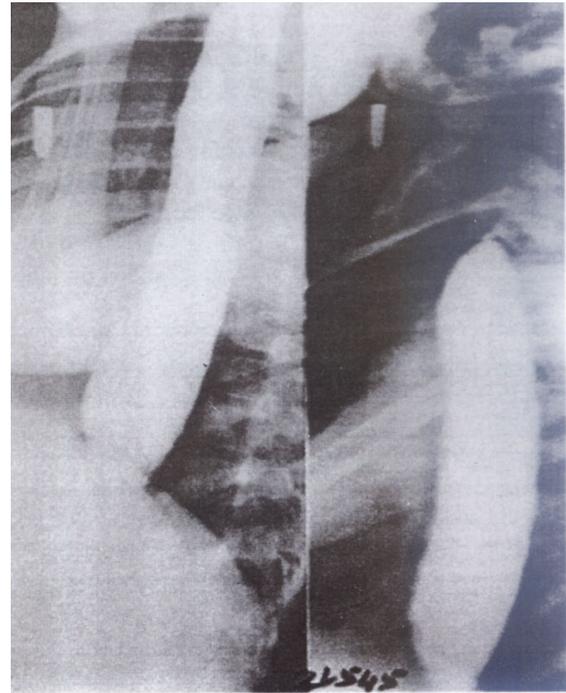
Barium swallow x-ray showing gross dilatation of oesophagus
